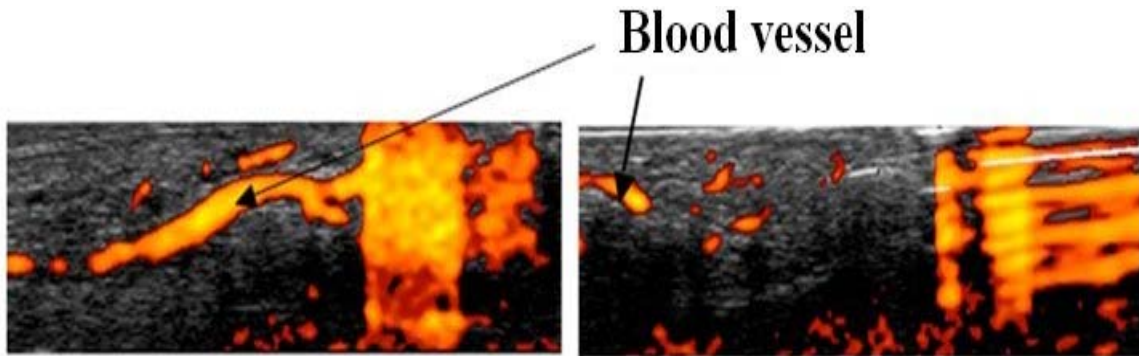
Power Doppler image of blood vessel in finger with flash artifact (left) and reverberation artifact (right).
